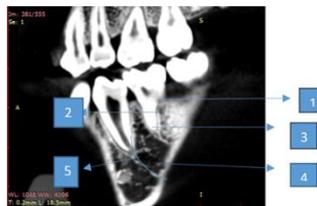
Anatomy of CBCT images assessed by observers 1. Enamel, 2. Dentin 3. Pulp chamber 4. Root canal, 5. Root length.
